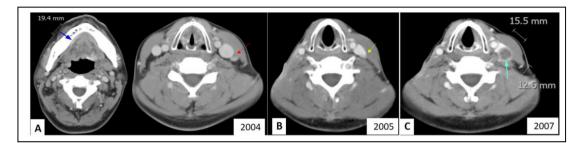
The series of computed tomography (CT) images with contrast medium. (A) Pre-operative CT image in 2004. The blue arrow indicated the location of the primary lesion. The red arrow marked a lymph node, ovoid in shape which was considered as normal. (B)Post-operation first-year follow-up CT image of the neck. No metastatic lesion was noted over both sides of neck. The previous lymph node, marked by yellow arrow, was still regarded as normal. (C) Post-operation third-year follow-up CT. A central necrotic lymph node, marked by the light blue arrow, at the left neck level III was found.
